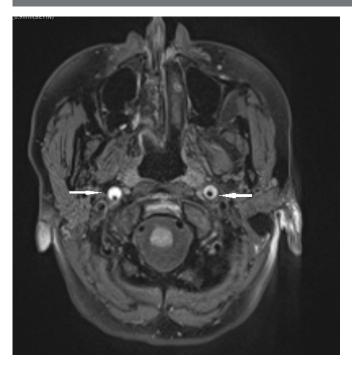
Fat-suppressed neck MRI reveals hyperintensities suggestive of intraluminal hematoma in the cervical segments of both internal carotid arteries (ICAs) from the bulb onwards (white arrows).
